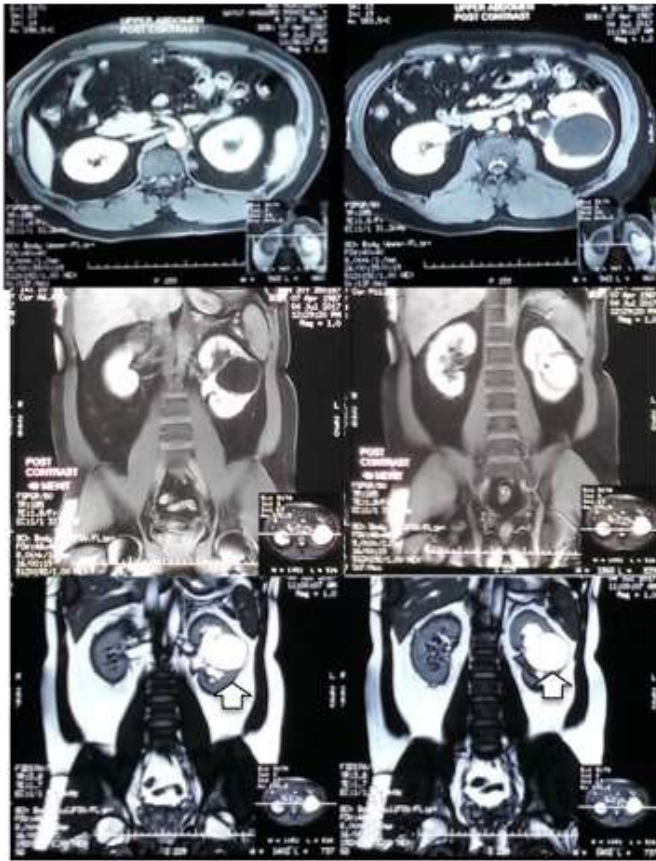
MRI Abdomen wedge Axial, Coronal T1Fat Sat, T2 Fat Sat, 2DFIESTA, 3D MRU without contrast, followed by T1FS with intravenous Gadolinium contrast. The post-contrast filling diverticulum is indicated with a white arrow.
